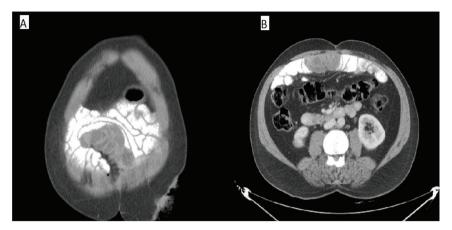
Internal hernia is mostly found incidentally, the literature has reported that sometimes accompanying malignancies cause herniation (1,2). In cases with an incidental internal hernia, atypical localization of the intestinal loops is often present without obstruction in the lumen. Internal hernias occasionally show spontaneous reduction and are often confused with many diseases (3,4). Contrast-enhanced coronal (A) and axial (B) sections of abdominal computed tomography (CT) imaging revealed a suspicious, cystic-necrotic appearing lesion mimicking the serosal implant on the anterior abdominal wall. The patient had a history of low anterior resection (LAR) after neoadjuvant chemoradiotherapy. The patient had no clinical symptoms, and tumor markers were at a normal level. The mesenteric fatty planes adjacent to the lesion were homogeneous, and no additional findings consistent with malignancy were found on the contrast-enhanced diagnostic abdominal CT.
